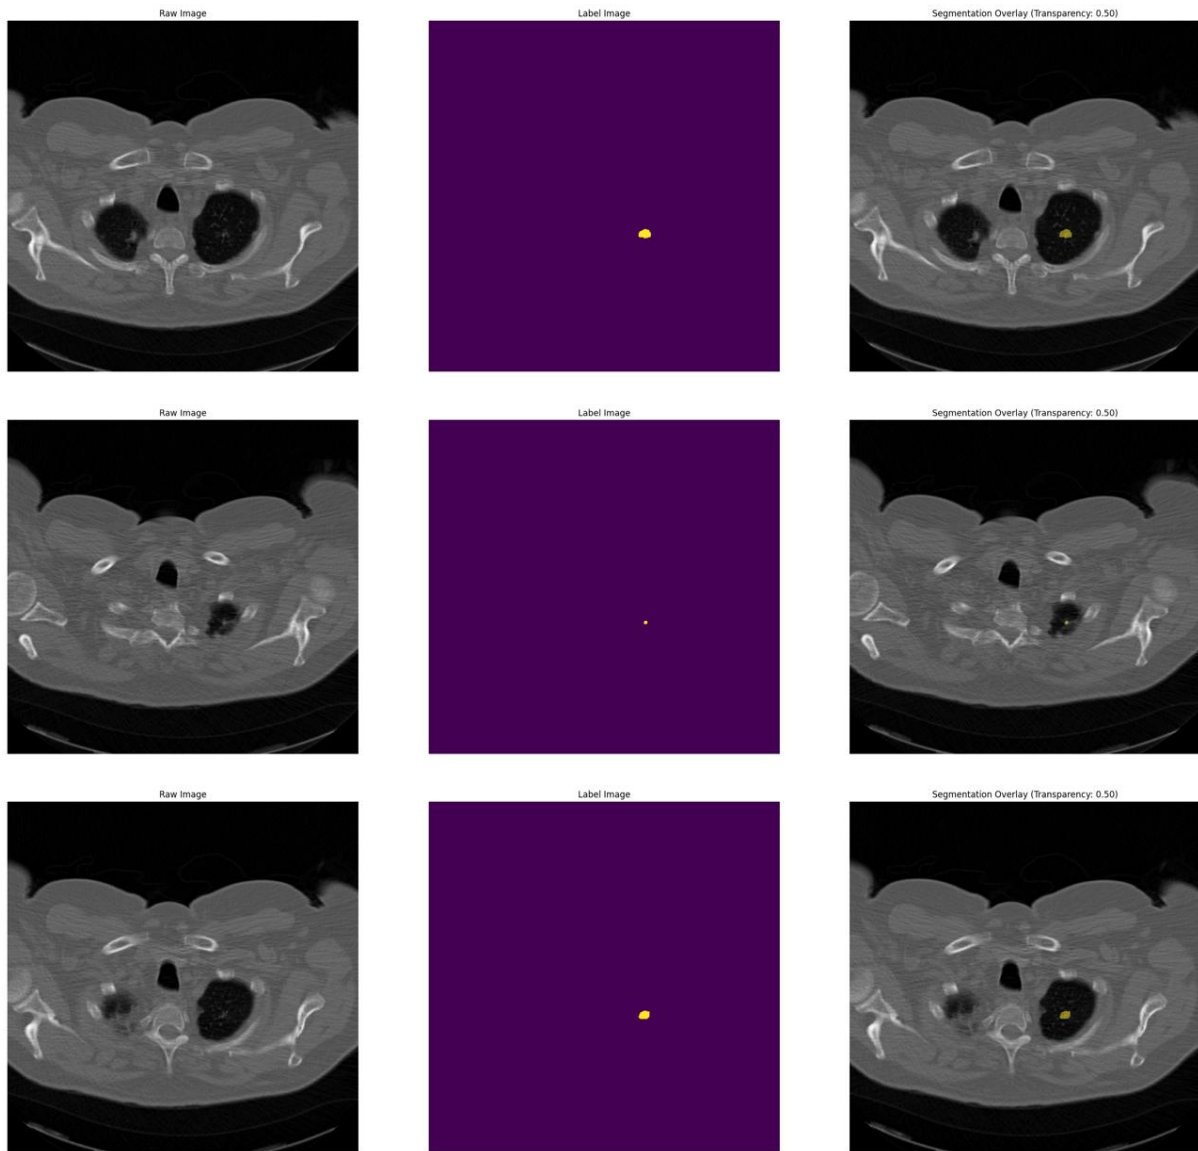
Overlay of the predicted nodule mask on three different CT slices.
